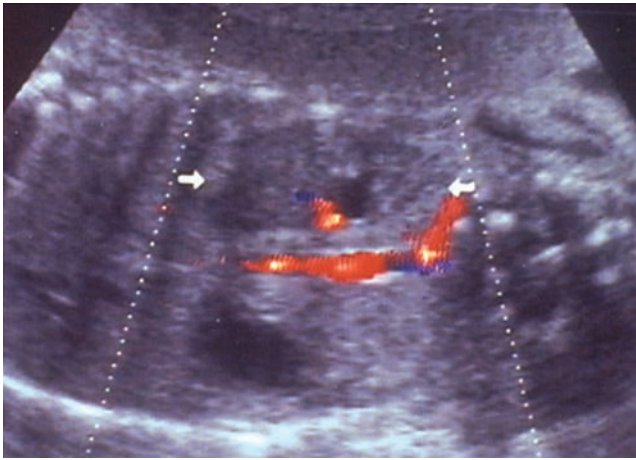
Unilateral renal agenesis. Renal artery in Doppler color. Notice the absence of the renal artery.
